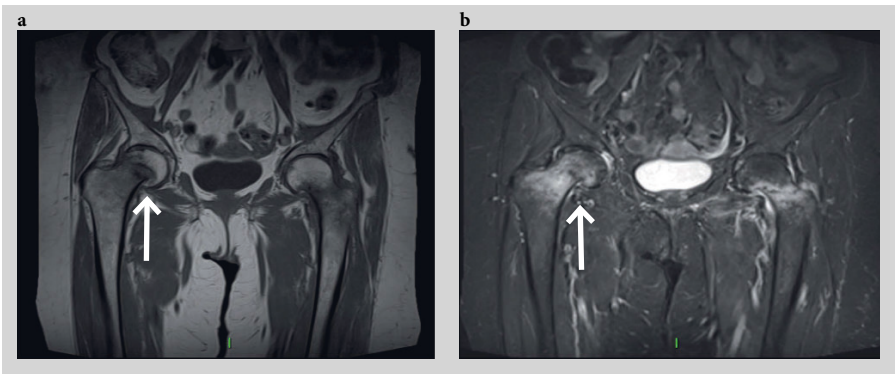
Bilateral insufficiency fractures of femoral necks. This woman has been taking corticosteroids for many years and presented with proximal leg pain which was actually referred pain from the fractures of the hips. The MRI reveals fracture lines of the right femoral neck (arrow) with bone marrow edema and impaction (a). On the left side, similar findings are present without definite impaction or displacement (b).
